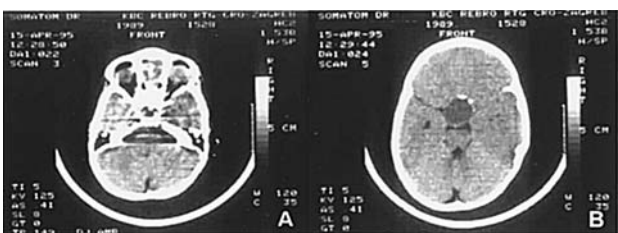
CT images before the surgical removal of craniopharyngioma in 1995.
